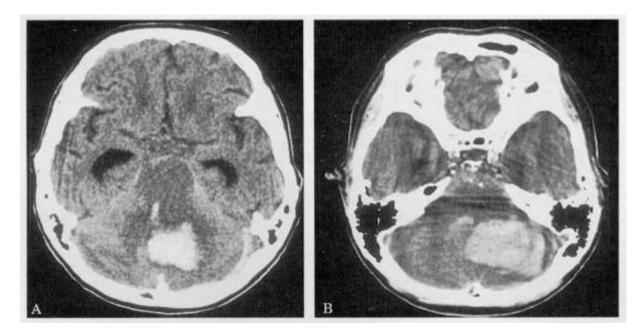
CT scan images A and B, revealing a left hemispheric cerebellar haematoma, extending to the vermis, with haemorrhage invading into the IV<sup>th</sup> ventricle
